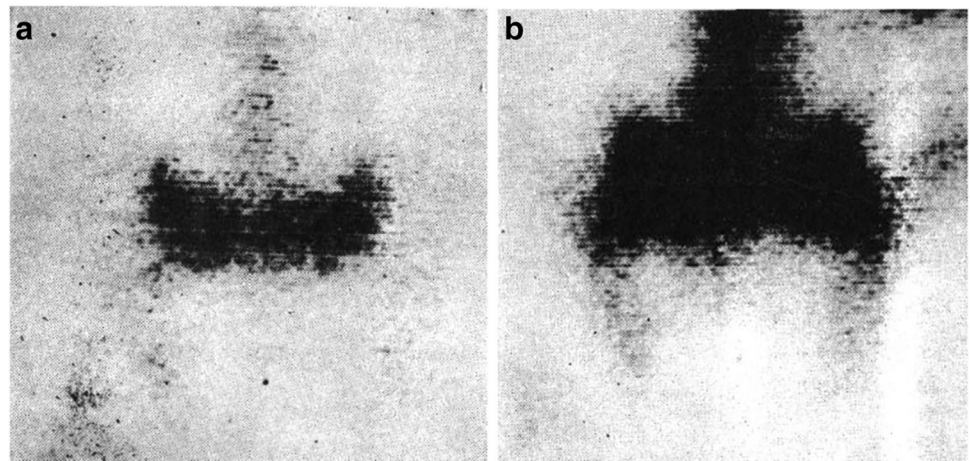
Liver scintigraphy image of hepatoma (from ref. [2], permitted by the Korean Society of Nuclear Medicine). There is a photon defect in the right hepatic lobe corresponding to the hepatoma
